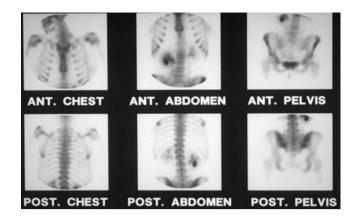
Normal Bone scan - Static views (spot) of 99mTc-MDP Skeletal scintigraphy show symmetrical distribution of radiotracer in the skeleton.
